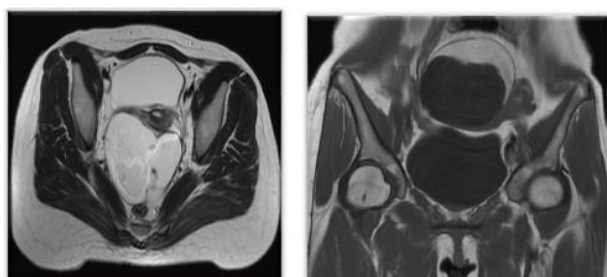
MRI pelvis- confirmed the presence of bilateral dermoid cysts.
